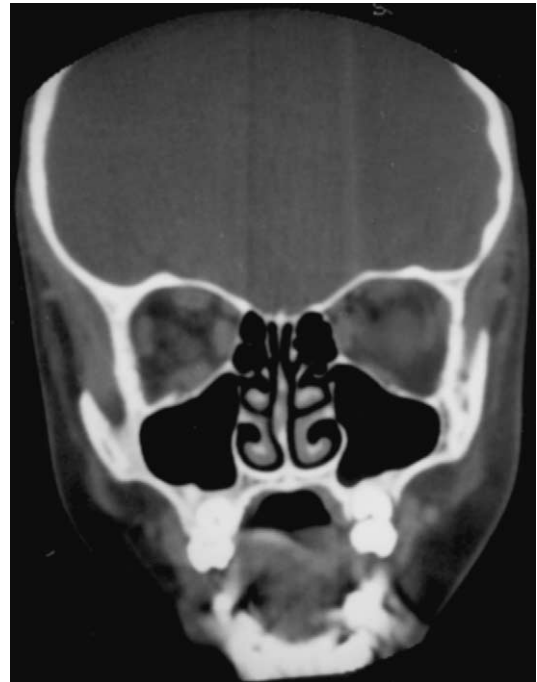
Postoperative coronal computed tomographic scan shows resolution of the soft tissue incarceration and repaired orbital floor with septal cartilage.
